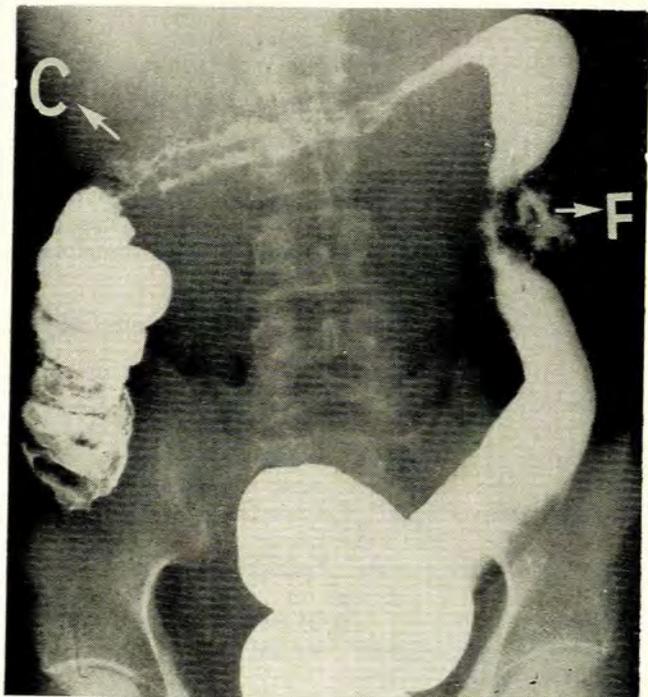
X-ray film of a barium enema examination of a patient with multiple segments of Crohn's disease of the colon who developed colocolic fistula from the descending colon.
